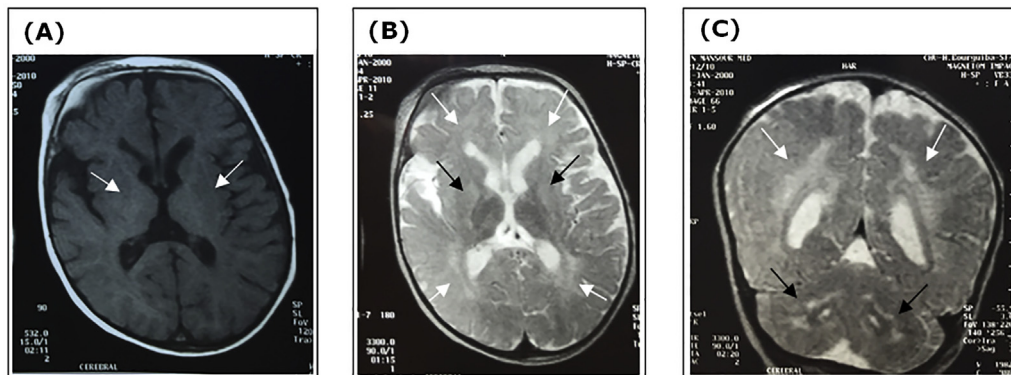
Brain MRI findings in Patient 1: (A) Axial T1-weighted image shows bilateral hypointensity in the lenticular nucleus (White arrows), (B) Axial T2 weighted shows an abnormally high signal intensity in the lenticular nucleus (black arrows) and in the bilateral periventricular white matter (White arrows), (C) Coronal T2 weighted shows an abnormally high signal intensity in the bilateral periventricular white matter (White arrows) and the bilateral dentate nucleus (black arrow).
